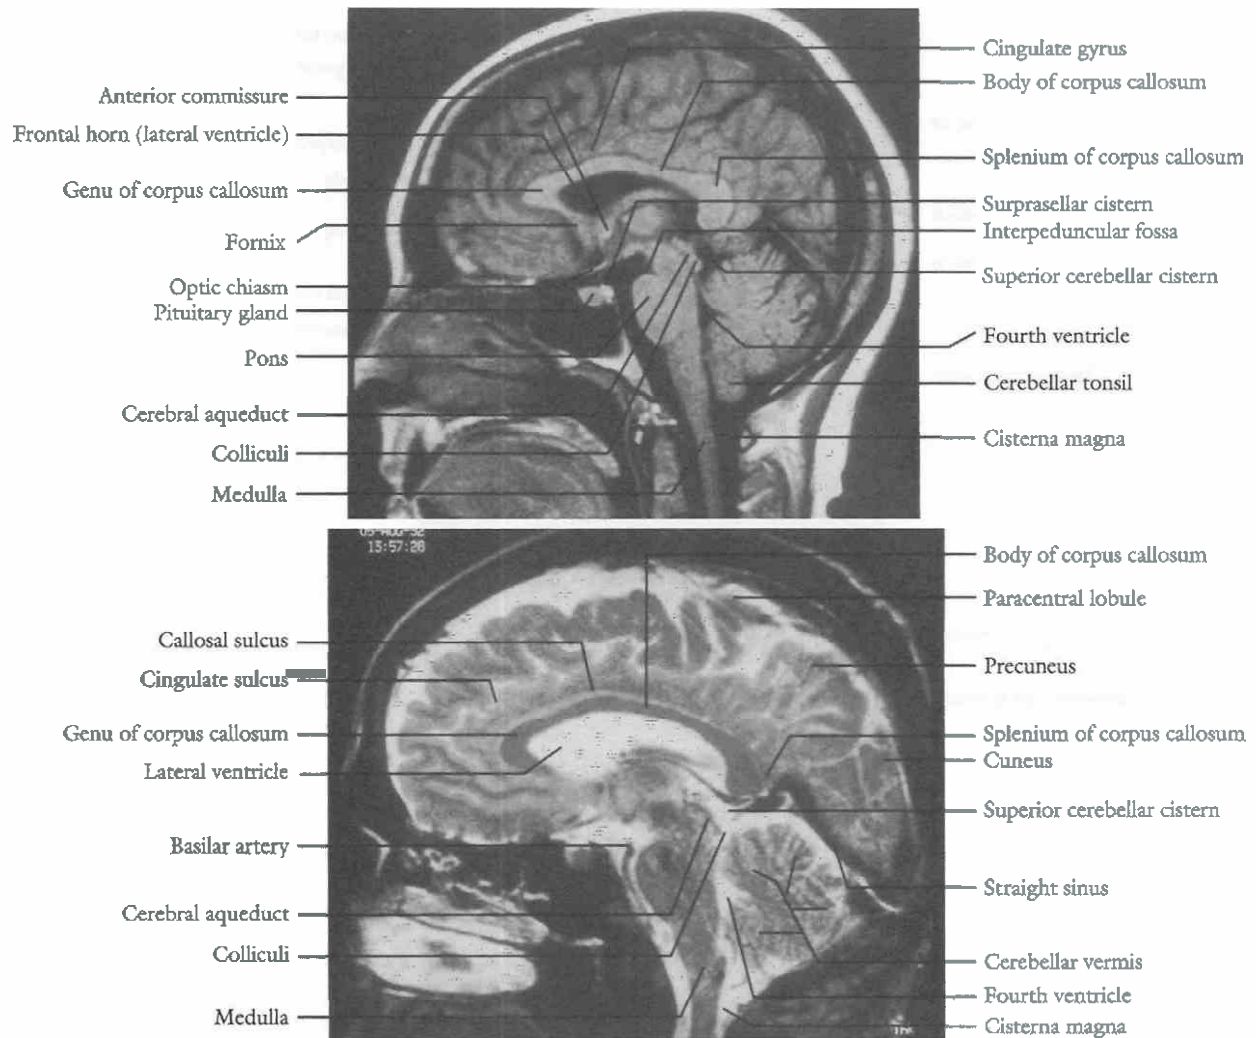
Top*, Sagittal T1 MRI scan at the midsagittal level. *Bottom*, Sagittal T2 MRI scan at the midsagittal level.
